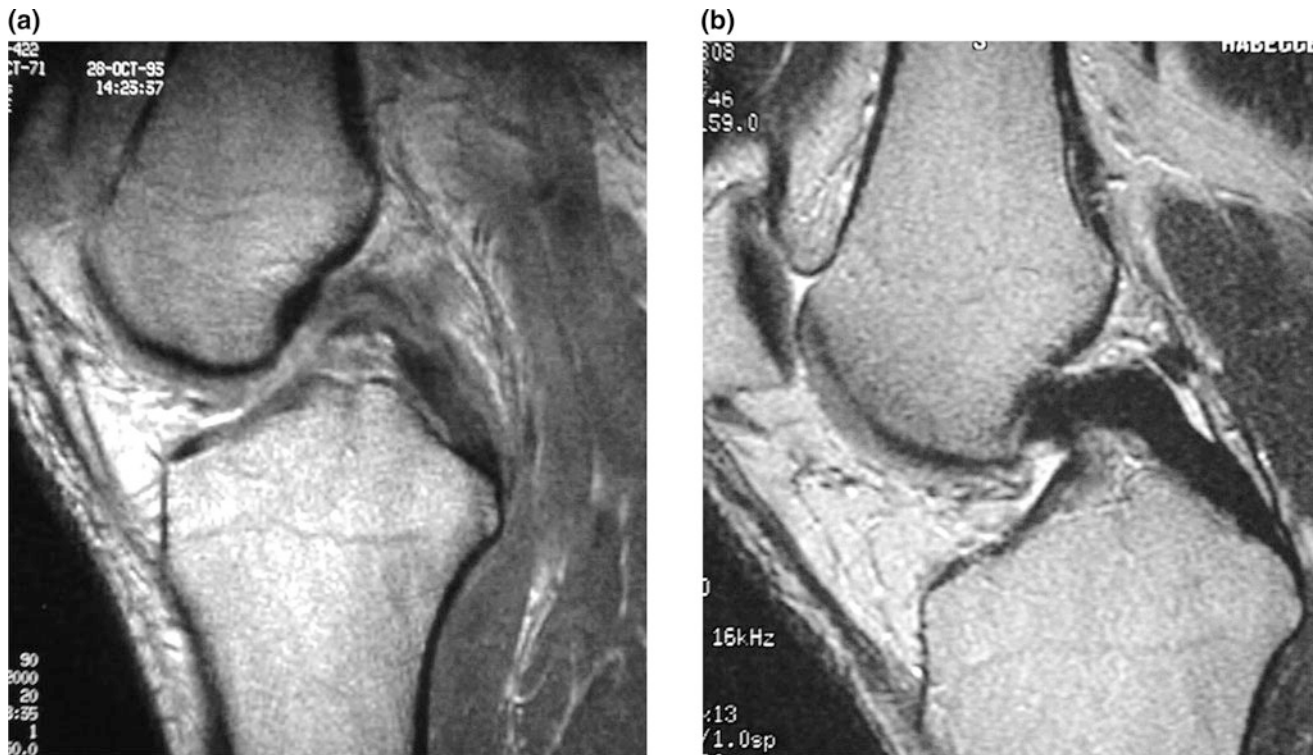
The MRI scan (a) of an acute PCL injury determined to be a complete PCL tear. A follow-up scan (b) at 8 months after injury shows the PCL to be in continuity. Reprinted with permission from [52]
